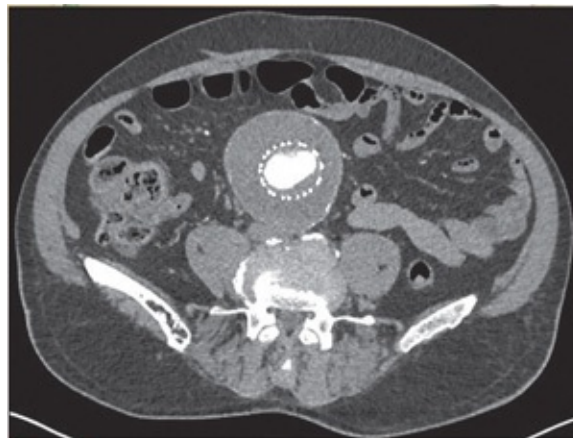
Abdominal aortic aneurysm CT: graft in place.
